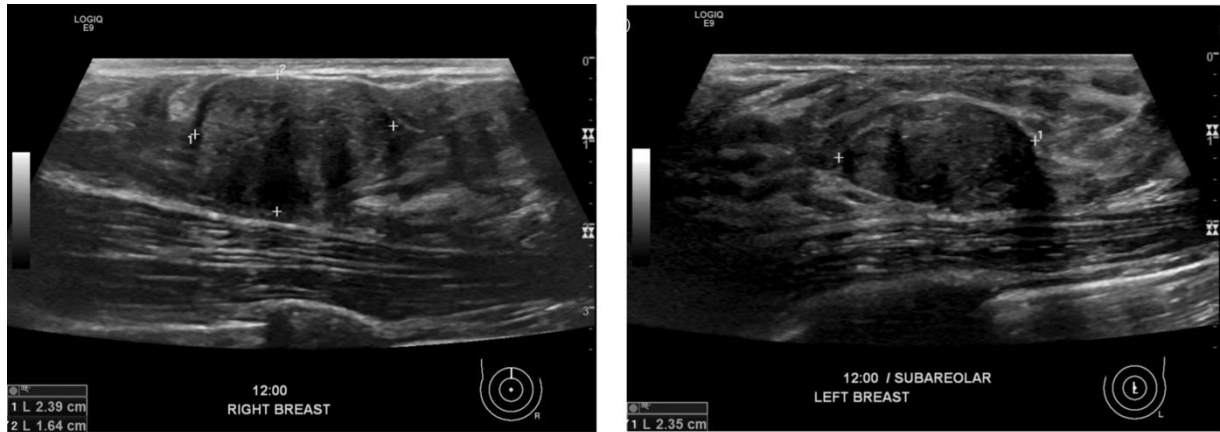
Ultrasonography of the Largest Masses Were Consistent with Ovoid, Well-circumscribed Fibroadenomas. Borders of the Masses are Marked with a White Cross.
